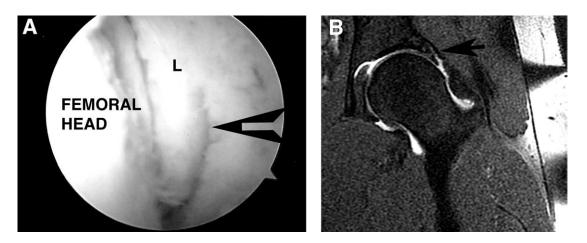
(A) Degenerative labral tear seen from the peripheral compartment. View is of a left hip and approximately the 3 o'clock position. Note the reactive synovial tissue laterally (arrow) (L, labrum). (B) T1-weighted MRI of lateral degenerative tear. Arrow indicates fragmentation of labral tissue.
